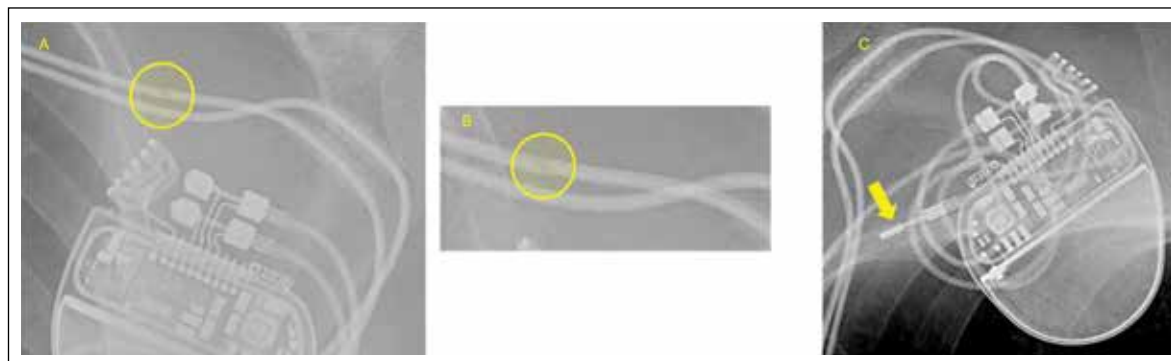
Zoomed frontal chest radiograph of the pulse generator and leads of a patient who had CHB underwent dual chamber pacemaker implantation in the past now presented with recurrent syncope. On evaluation, high capture threshold with acutely elevated lead impedance detected. A chest radiograph showed discontinuity with the dense part of the lead, suggesting lead fracture, shown in the inset (A, B). The fractured lead was capped and buried within the pocket (arrow), and a new ventricular lead was inserted (C).
